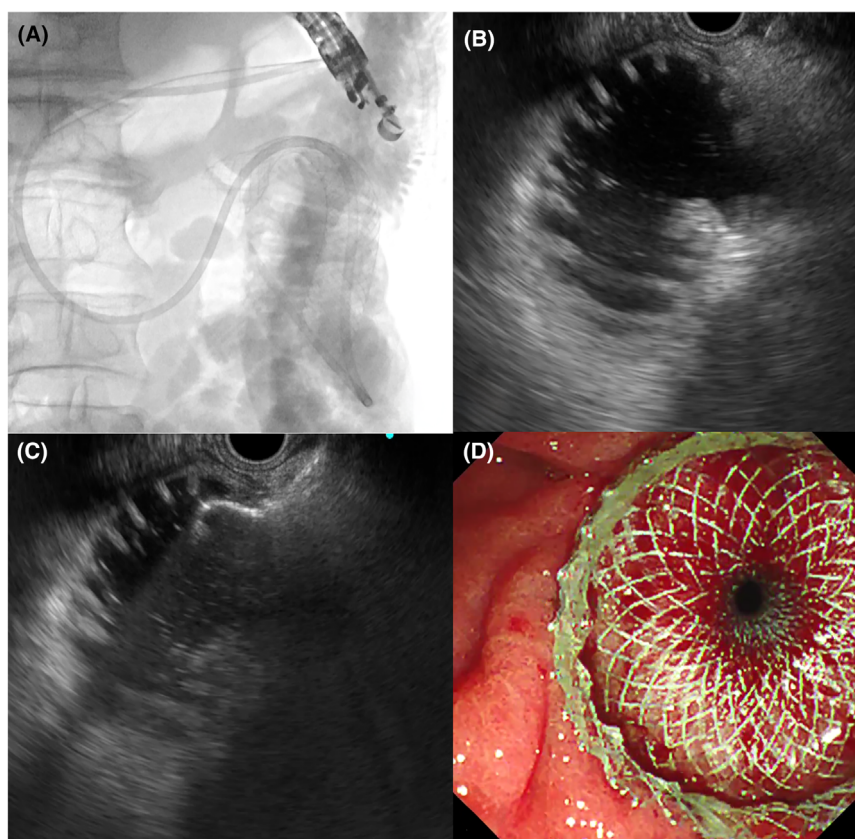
Endoscopic ultrasound (EUS)-guided gastroenterostomy with the DUBX through-the-scope catheter (Chess Medical, Montreal, Canada). (A) Insertion of the through-the-scope DUBX catheter. (B) Reattachment of the detachable injection ports on guidewire to the catheter after scope removal. (C) Attached detachable injection ports to the catheter. (D) Distended occluded segment of small bowel. (E) Distal flange deployed under EUS guidance. (F) Deployed proximal flange as seen endoscopically.
